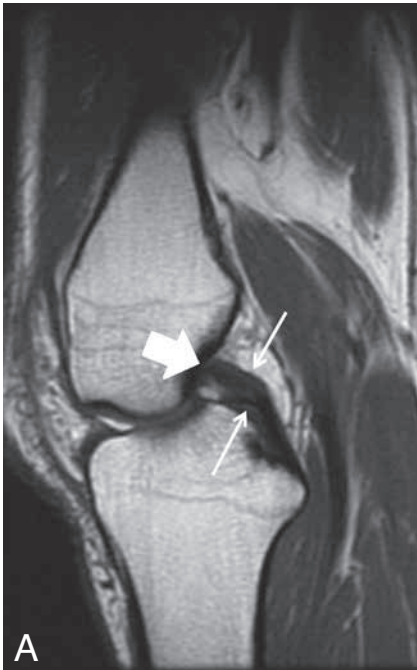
Sagittal T1-weighted image (A) and sagittal fatsuppressed T2-weighted image (B) of the right knee shows altered signal intensity in the central part of the PCL (bold arrow) with intact peripheral fibres (small arrows). This is also easily recognized on the coronal fatsuppressed T2-weighted images (C).
